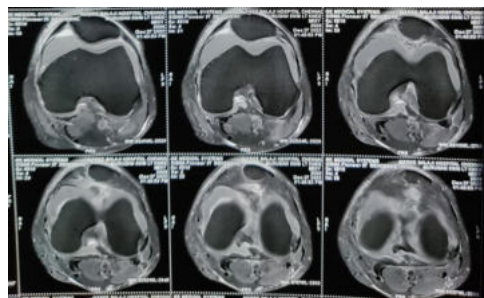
Axial view of MRI left knee shows signal
